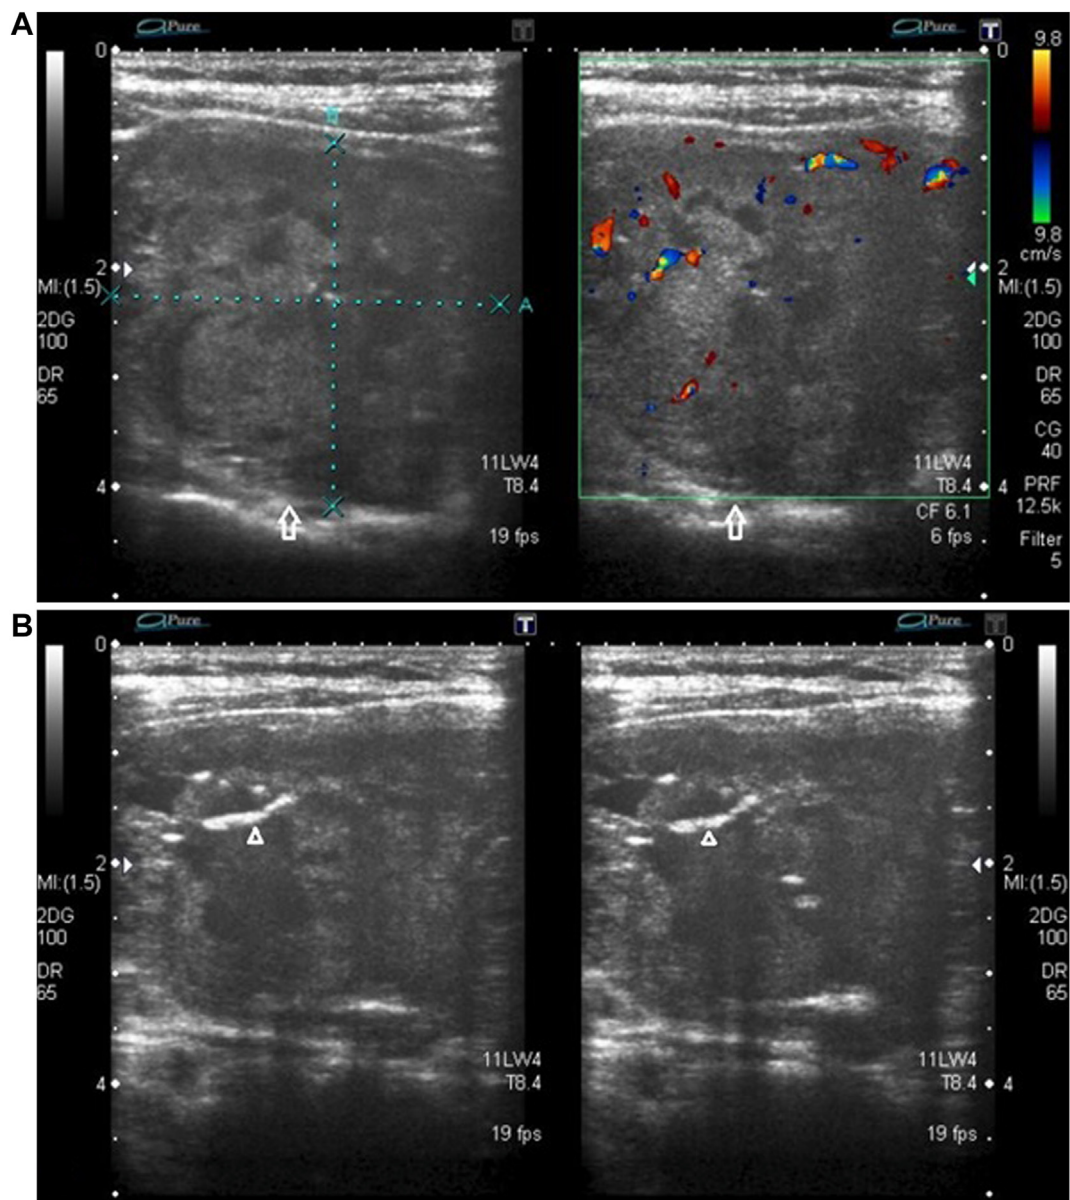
A through C, Ultrasound images of the thyroid gland showing bilateral nodular enlargement. Large well-defined heterogeneous rounded complex (with small cysts) nodule in the right lobe, measuring 35 × 33 mm (A and B, arrows), with multiple coarse calcifications (B, arrowheads). Inferiorly, the nodule showed extension into the sternum. Large well-defined rounded nodule (C, arrows) in the left lobe with multiple coarse calcifications (C, arrowheads). Internal vascularity was also observed on color Doppler imaging. No cervical lymphadenopathy. D and E, Ultrasound images of the thyroid gland showed an additional nodule in the right lobe (D, arrow), which was complex and well-defined with a few benign calcifications within it. E, An additional solid-appearing nodule within the isthmus of the thyroid gland (arrow), in keeping with a multinodular goiter.
